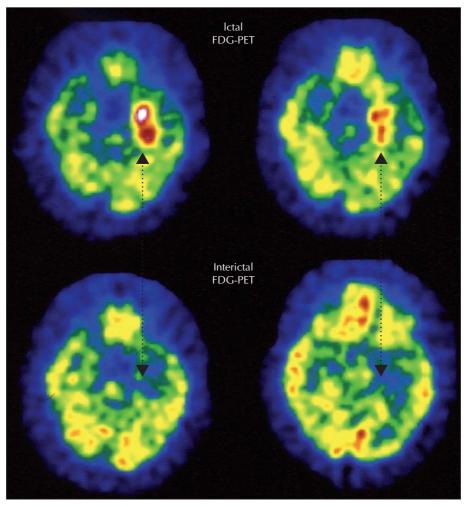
Ictal* [18F]FDG-PET. An ictal FDG-PET was obtained in a patient who presented several epigastric auras during the 10 minutes following FDG injection, showing a clear-cut left mesial temporal glucose hypermetabolism. The latter was replaced by a left mesial temporal hypometabolism on a second FDG-PET performed interictally.
